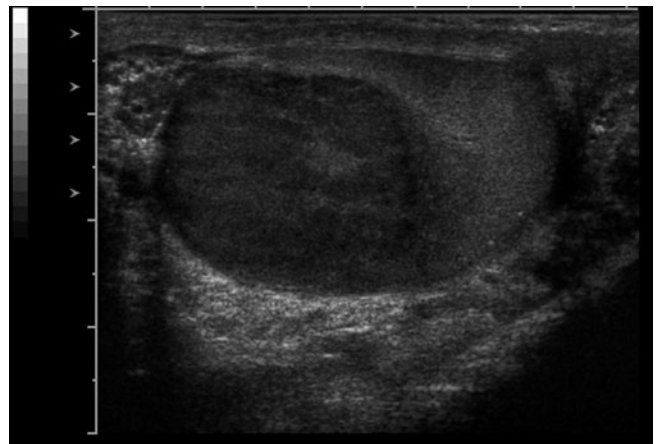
Seminoma. Sonogram demonstrates a minimally heterogeneous, well-marginated intratesticular mass
